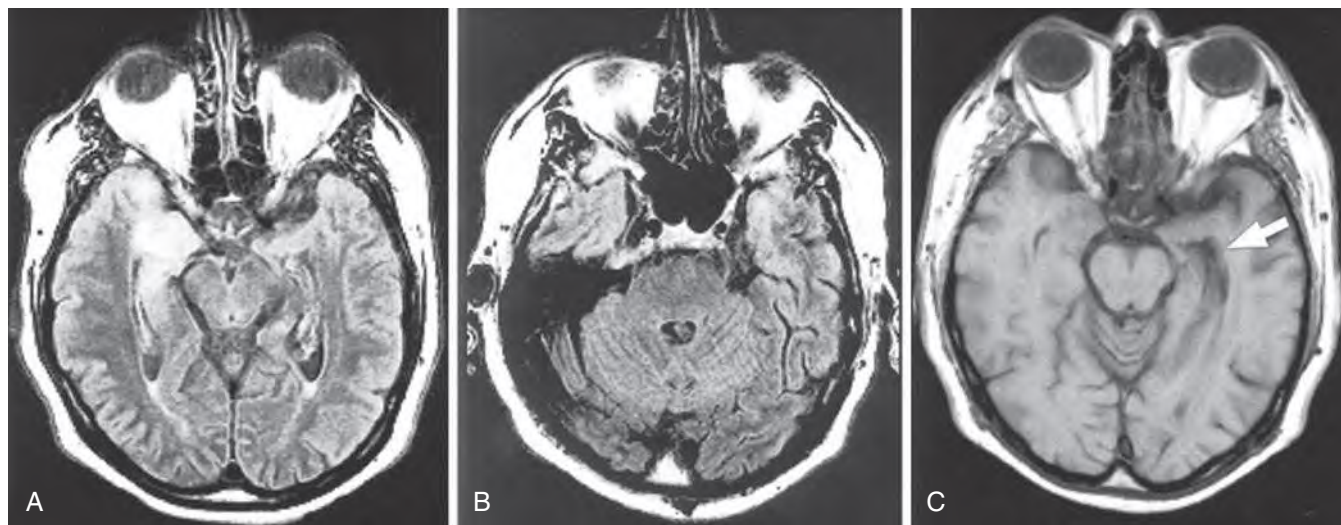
Magnetic resonance images of general paresis in a 50-year-old man with a 3-month history of progressive dementia and seizures. (A) Axial fluid-attenuated inversion recovery (FLAIR) image obtained at midbrain level. (B) Axial FLAIR image obtained at the level of the pons. Asymmetrical bilateral signal hyperintensity in the mesial temporal lobes is greater on the right side than on the left. (C) Axial T1-weighted image obtained at the level of the low midbrain showing mild left temporal lobe atrophy, evidenced by dilatation of the temporal horn (arrow). (From Bash S, Hathout GM, Cohen S. Mesiotemporal T2-weighted hyperintensity: neurosyphilis mimicking herpes encephalitis. *Am J Neuroradiol.* 2001;22:314–316.)
